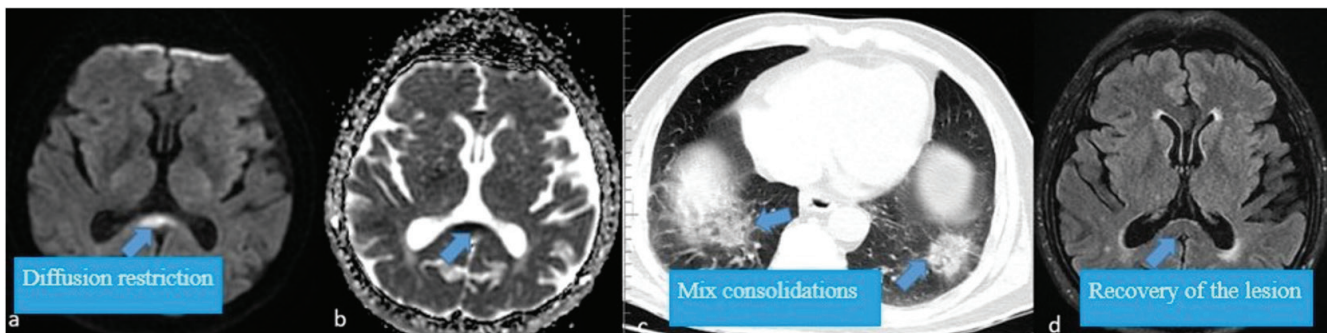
(a, b) Fifty eight years old, male patient with splenic diffusion restriction in DWI (c) Mix consolidations in bilateral posterior segments of lower lobes in axial thorax computed tomography mediastinal window (d) Completely regression of lesion in the axial FLAIR sequence of control cranial magnetic resonance imaging after one and a half month later (arrows)
